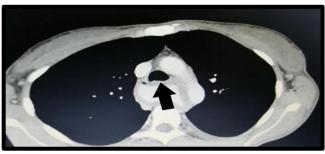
(A) Barium swallow showing a short tight gastroesophageal stricture with proximal esophageal dilatation and tertiary contraction. (B) Contrast enhanced CT thorax showing grossly dilated distal esophagus (arrow) in which causes compression of the left lower lobe bronchus.
